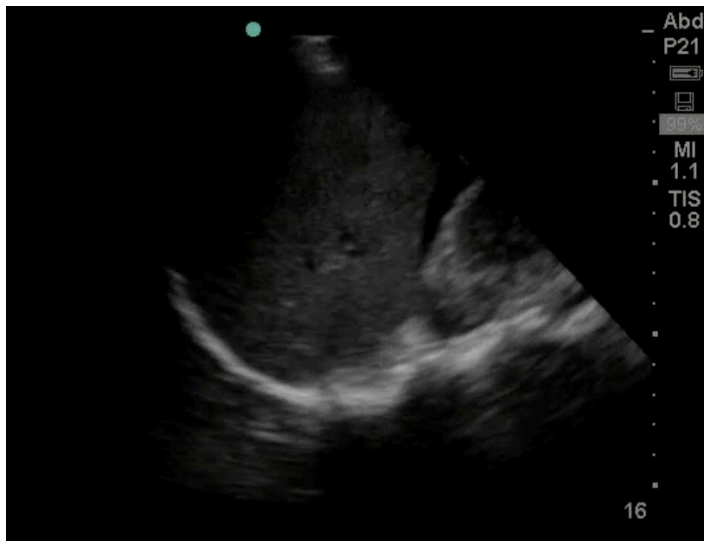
Focused Assessment with Sonography examination demonstrating free fluid in Morison's pouch.
